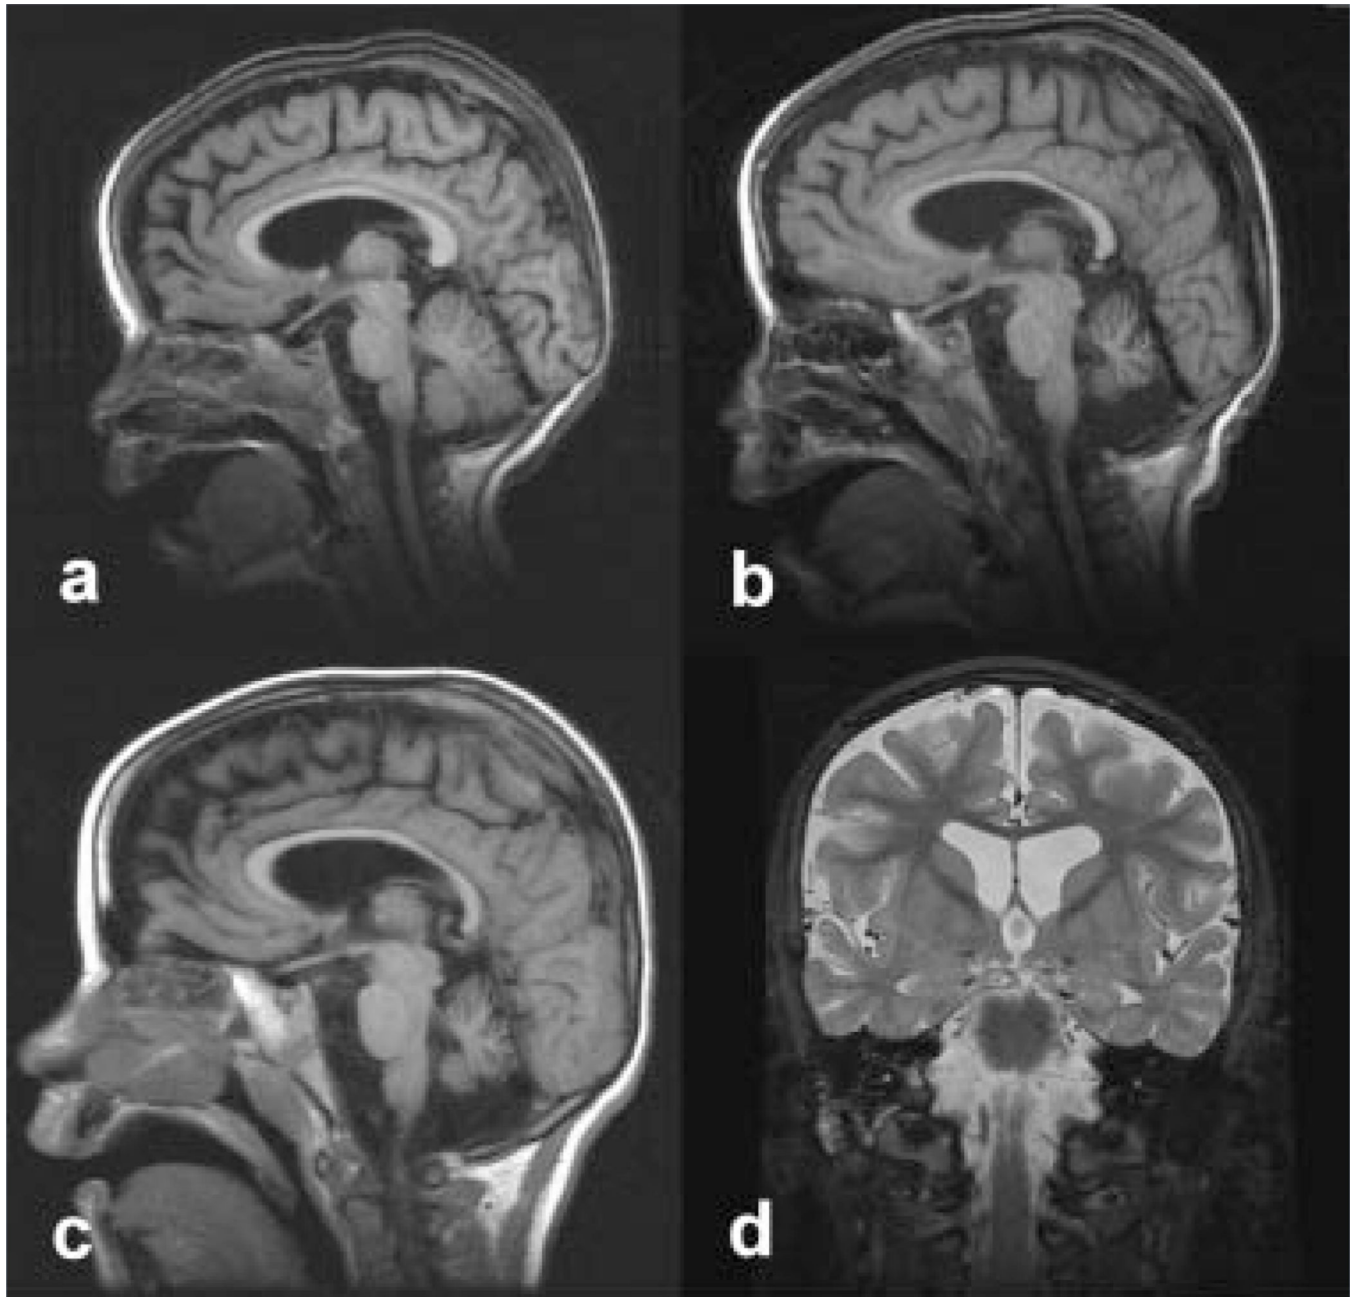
Neuroimaging features. Serial MRI images in individual IV-3 demonstrated progressive cerebellar and to a lesser extent cerebral atrophy and white matter loss at ages (a) 8 months, (b) 3½ years, and (c) 5½ years. d: Stir images performed at age 5½ years failed to demonstrate excess brain iron deposition.
